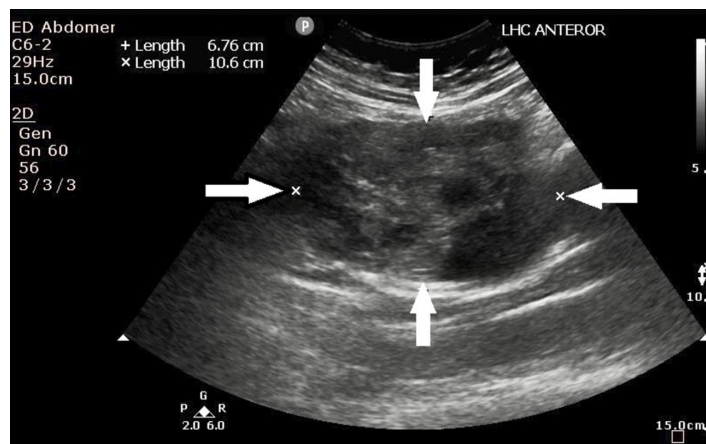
Point-of-care ultrasound of the left hypochondrium showing a heterogeneous mass as outlined by the white arrows, later determined to be a gastrointestinal stromal tumor.
